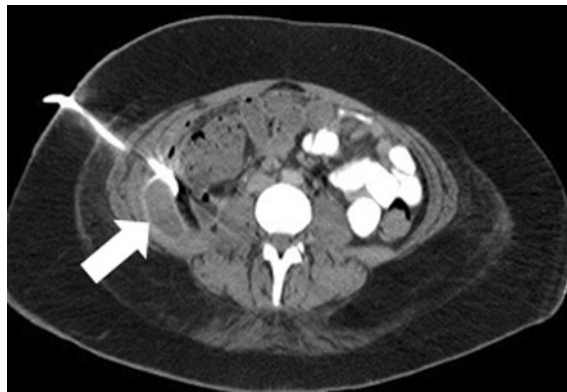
Abscess with drain in place in a 14-year-old-female who presented with abdominal pain. Axial contrast-enhanced CT reveals a drain in place within an abscess (*arrow*) from a ruptured appendix. The appendix could not be identified
